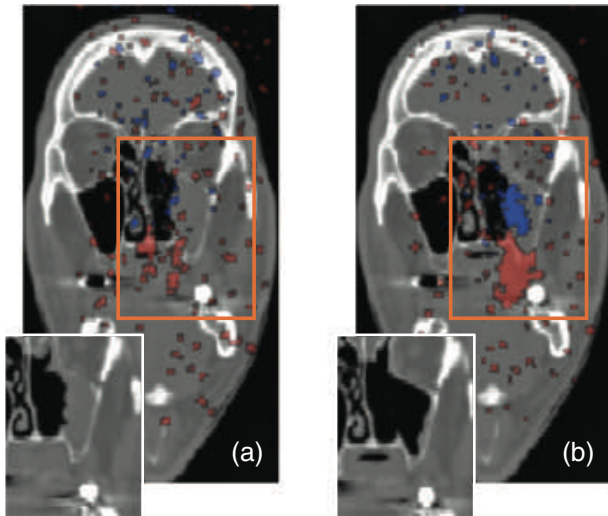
p -value maps overlaid on the planning CT, resulting from the statistical analysis of the PET images corresponding to the first control CT (a) and the second control CT (b). The small insets in the slices show actual situation in the control CTs that gave rise to the maps
